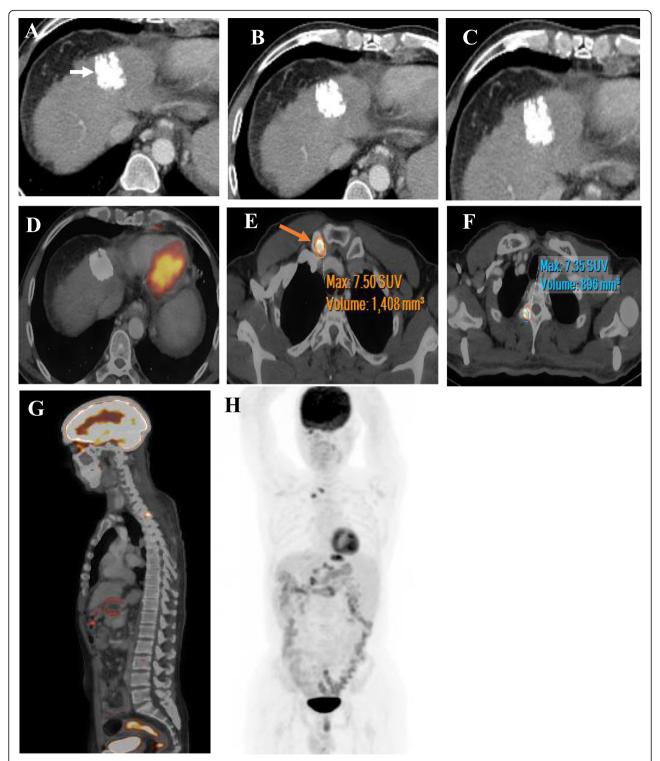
a–c CECT phases showing lipiodol concentration at chemoembolized lesion at the left lobe (arrow). d Fused PET/CT images showing well ablation of the embolized lesion with no activity detected. e Axial fused PET/CT shows hypermetabolic metastatic bony lesion at the right clavicle(red arrow). f Axial fused PET/CT shows hypermetabolic metastatic bony lesion at D2 vertebra. g Sagittal fused PET/CT whole spine shows D2 osseous deposit. h 3D CTAC summarizing the whole study
